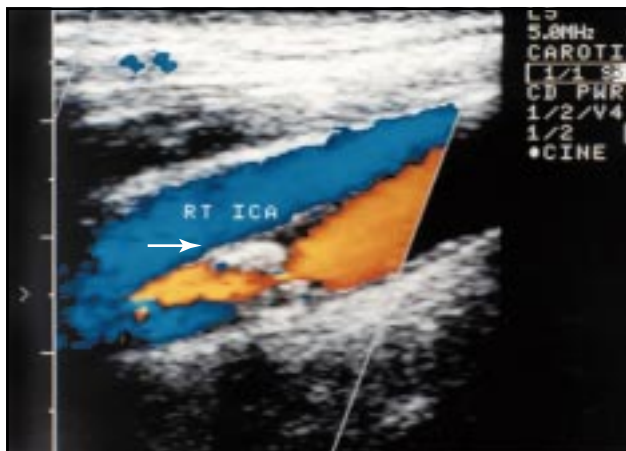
Colour doppler carotid duplex scan showing a high-velocity stenosis (arrow)
